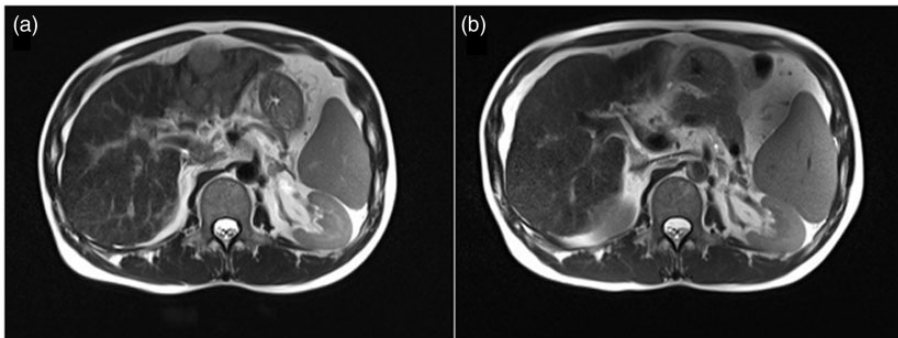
Magnetic resonance imaging of case I. (a) Multiple masses before treatment. (b) The masses disappeared after treatment.
